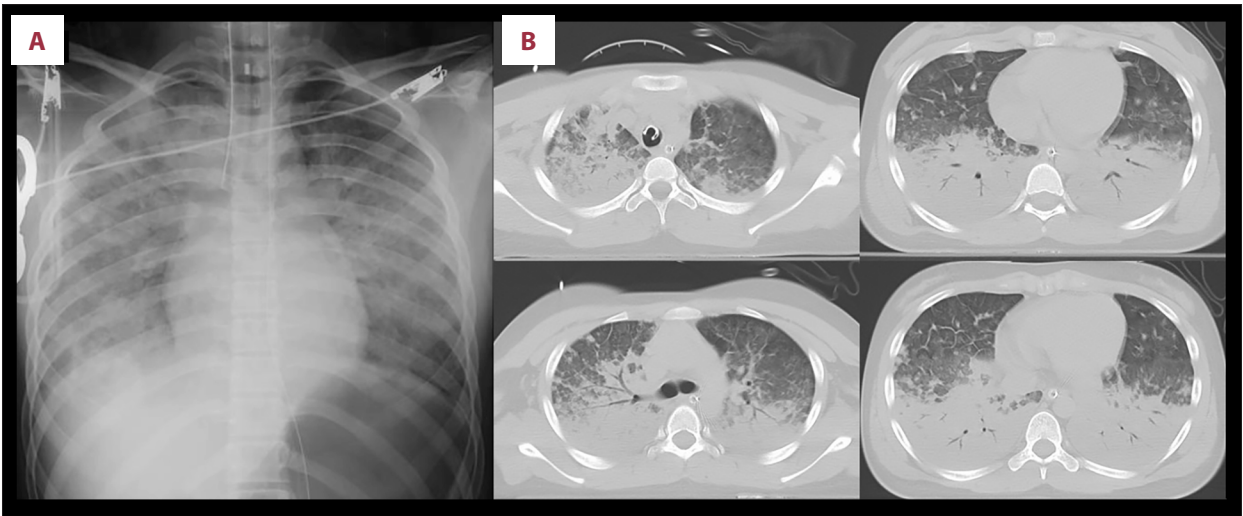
Chest imaging on admission. (A) Chest X-ray demonstrated bilateral diffuse pulmonary infiltrates. (B) Chest computed tomography revealed diffuse bilateral ground-glass opacities and consolidation.
